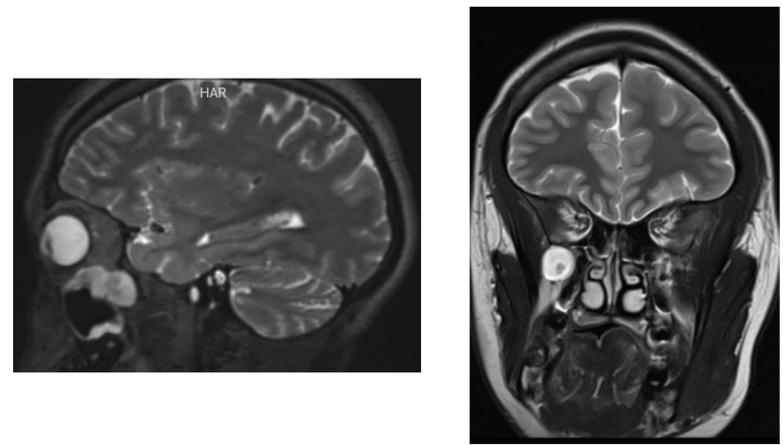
Imaging at the time of presentation. MRI exam demonstrating a T2 hyperintense, enhancing lesion along the right inferior orbital fissure.
